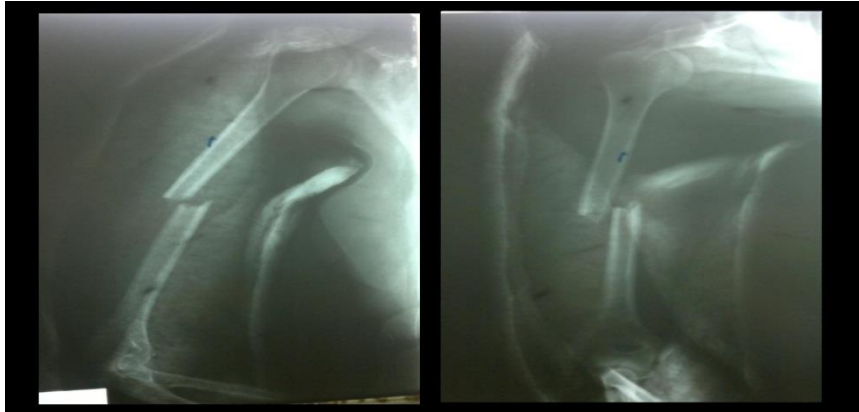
a): prior operation X-ray
